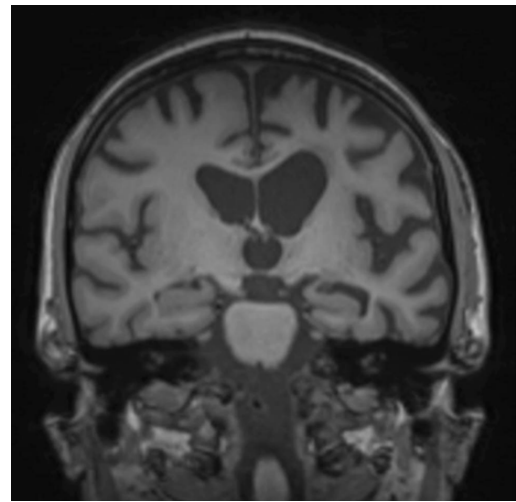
Magnetic resonance imaging of a dementia patient [15].
